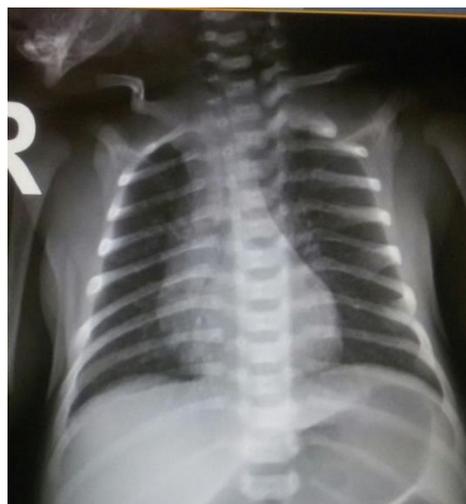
Chest radiograph of the newborn, obtained on 28 March 2020, demonstrating mild patchy infiltration in lung parenchyma with no abnormalities in the heart and palate
